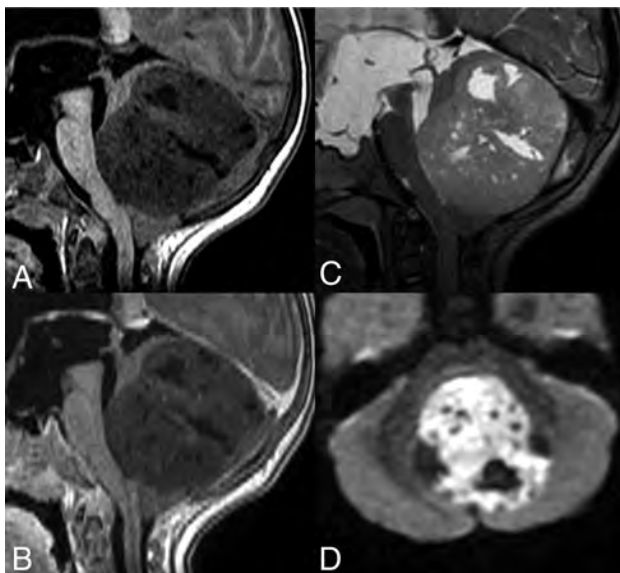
Brain imaging of patient 3. Sagittal plane (A–C) MR images show a large midline vermian tumor, with mass effect on the fourth ventricle causing hydrocephalus. The tumor displays hypointensity on the T1-weighted image (A), hyperintensity on the T2-weighted image (C), and no enhancement after contrast media injection (B). Diffusion signal is high (D) with low ADC.
